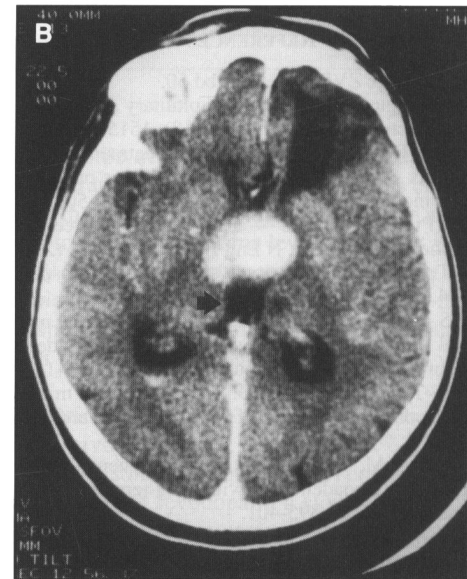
Post-operative CT scan showing a left thalamic infarction.
